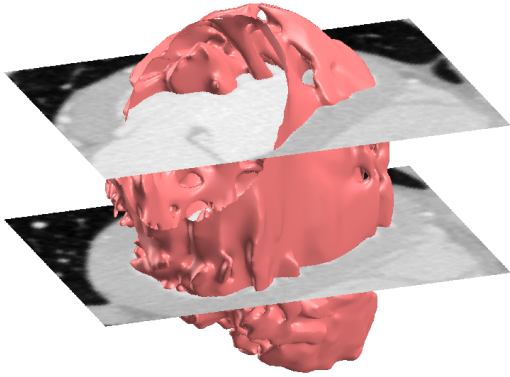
View of a detailed mesh extracted from CT data using isosurfacing. Note the complex trabeculae inside the heart.
